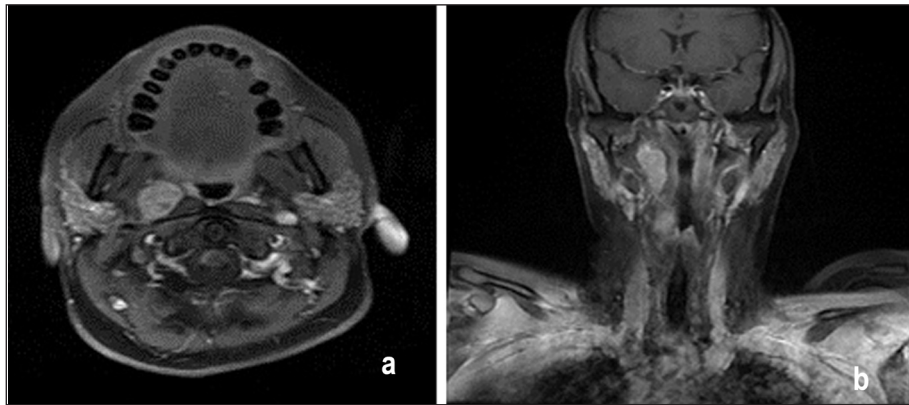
Magnetic resonance imaging scans in axial (a), coronal (b) planes demonstrating papillary thyroid carcinoma metastasis laid in the prestyloid compartment.
